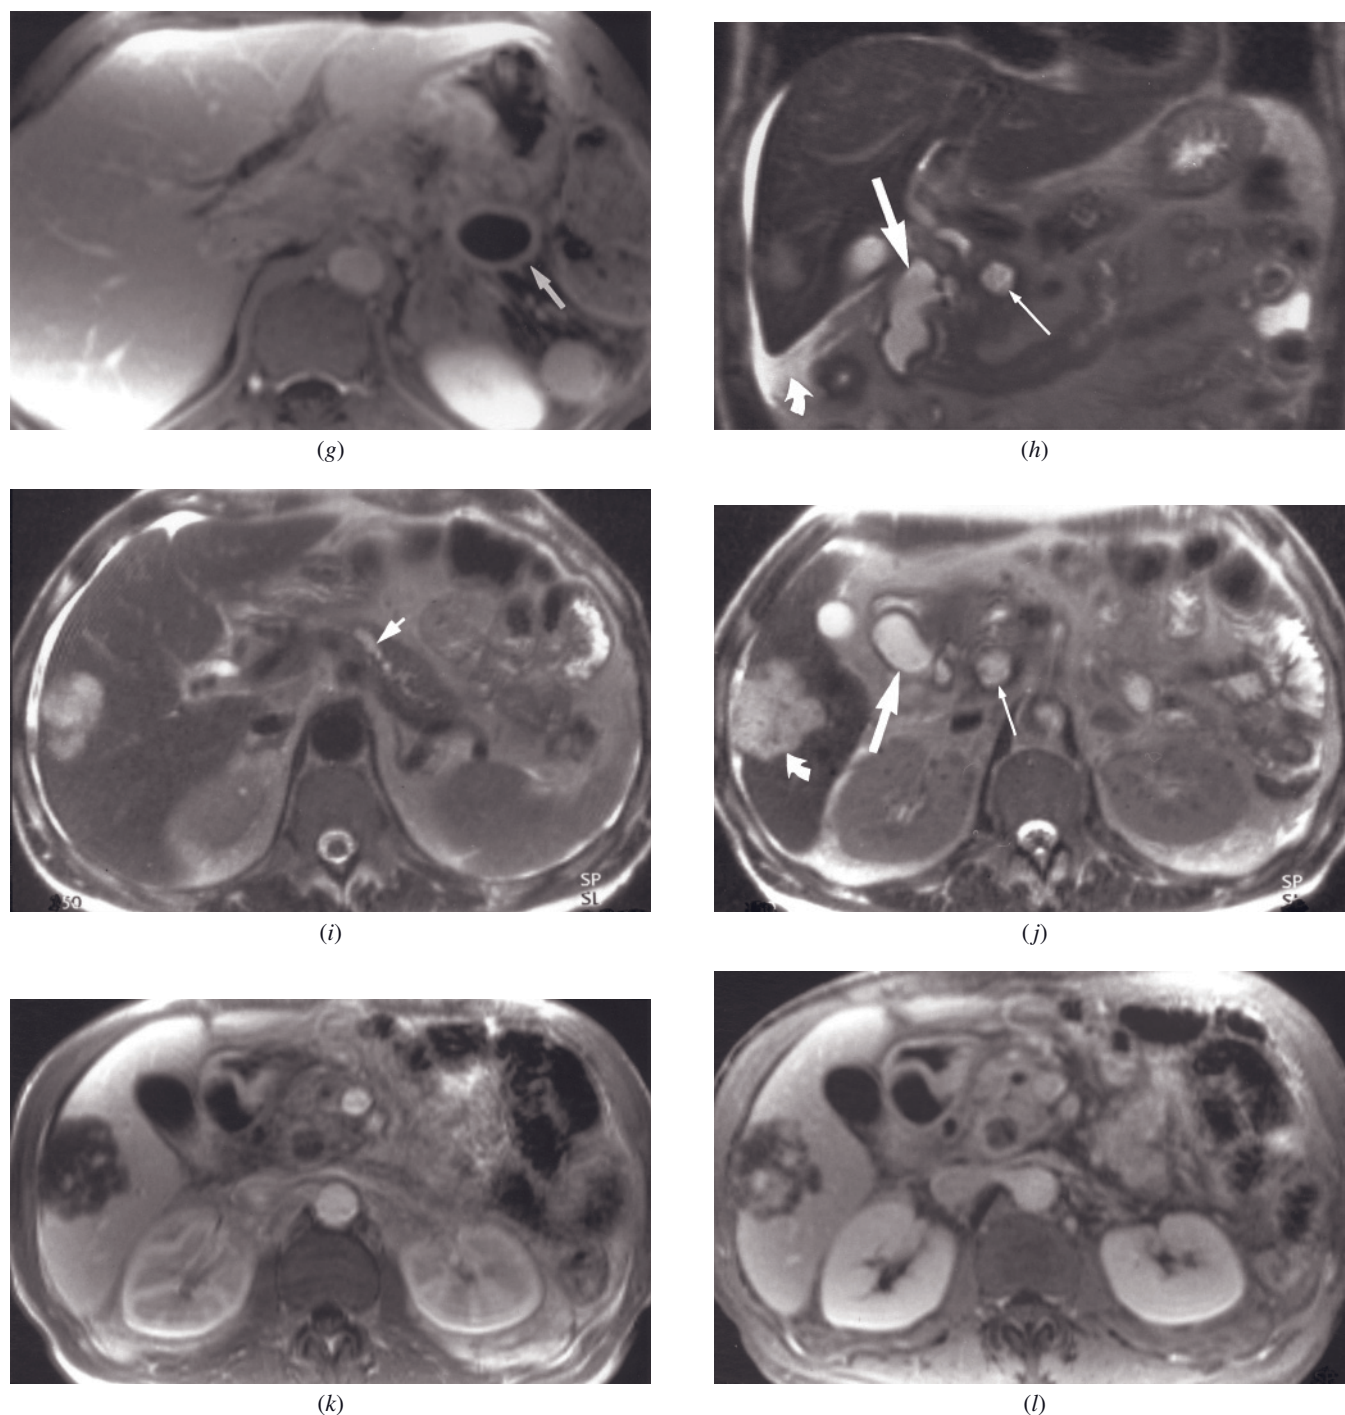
(Continued) SGE (g) images. There is a pseudocyst (arrow, *a*) in the pancreatic tail, which has a thickened wall that exhibits progressive late enhancement (arrow, *g*). The pancreatic head and neck region (arrows, *d*) are enlarged (*d*, *f*) and exhibit low-signal on noncontrast fat-suppressed images (*d*) and diminished heterogeneous enhancement on immediate postgadolinium SGE images (*f*) consistent with focal acute on diffuse chronic pancreatitis. Note that renal corticomedullary difference is diminished on the noncontrast T1-weighted fat-suppressed image consistent with decreased renal function (*d*).
